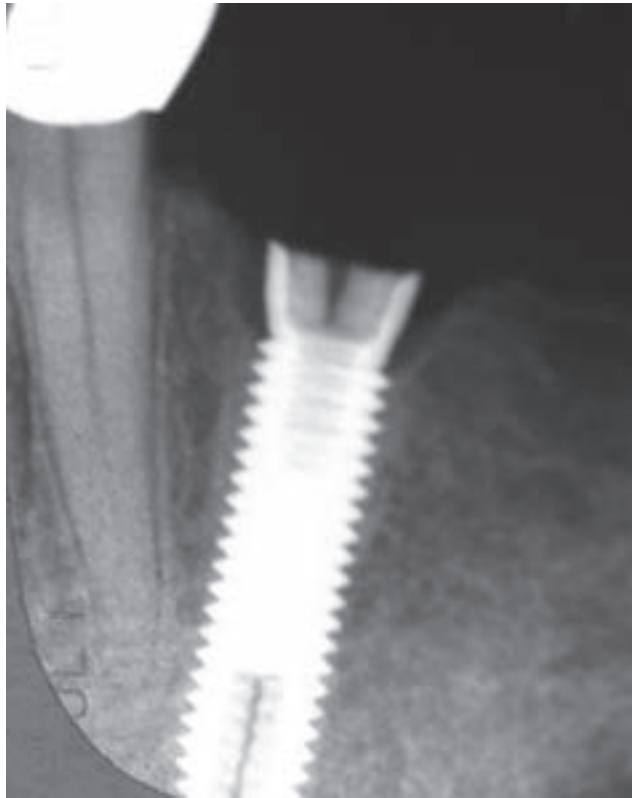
Radiographic view of fracture (flowering) of the coronal aspect of an implant.
